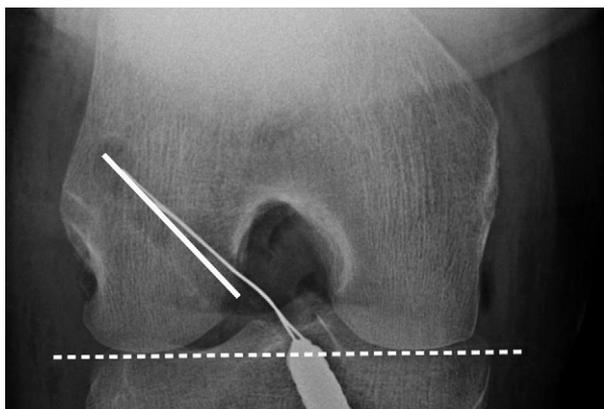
Notch-view radiograph of right knee (case 3). The femoral tunnel orientation (solid line) with reference to a line tangent to the distal aspect of the femoral condyles (dashed line) measured 47° . The center of the femoral tunnel, with respect to the clock-face position, was calculated to be at the 9:45 position.
